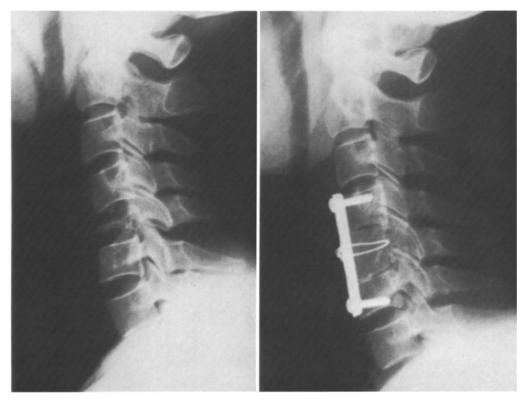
Preoperative (*left*) and postoperative (*right*) lateral X-ray films showing the pathological fracture of the C5 body due to myeloma, and the metal plate between C4 and C6, with wiring between the plate and the iliac bone graft
